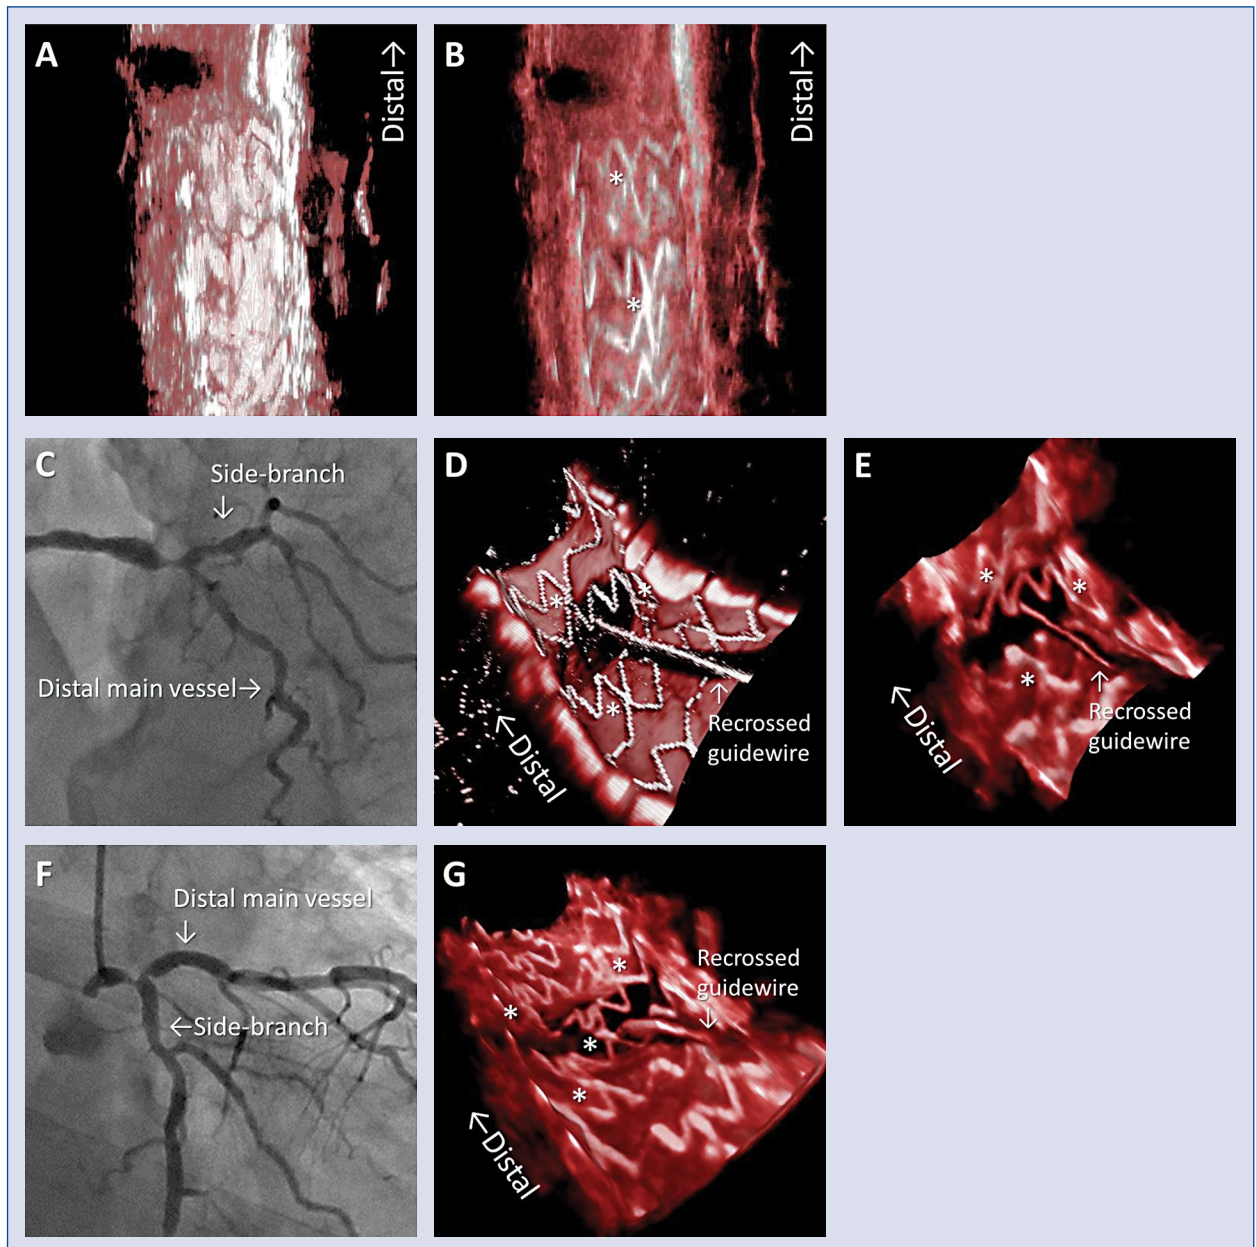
The stent-oriented three-dimensional (3D) intravascular ultrasound (IVUS). A. The longitudinal cut-away view of the 3D-IVUS reconstructed from the original IVUS images; B. The longitudinal cut-away view of the stent-oriented 3D-IVUS reconstructed from the minimum-filtered IVUS images. The baseline coronary angiogram (C), the longitudinal cut-away view of the stent-enhanced 3D optical coherence tomography (D) and the stent-oriented 3D-IVUS (E) of another clinical case (the crossover stent deployment on the bifurcation lesion with Ultimaster Tansei followed by guidewire recrossing). The jailing type and rewiring position can be confirmed by the stent-oriented 3D-IVUS as the link-connecting type and proximal rewiring. The baseline coronary angiogram (F) and the longitudinal cut-away view of the stent-oriented 3D-IVUS (G) of a clinical case with Xience Sierra (the crossover stent deployment on the bifurcation lesion followed by guidewire recrossing). Asterisks indicate stent links.
